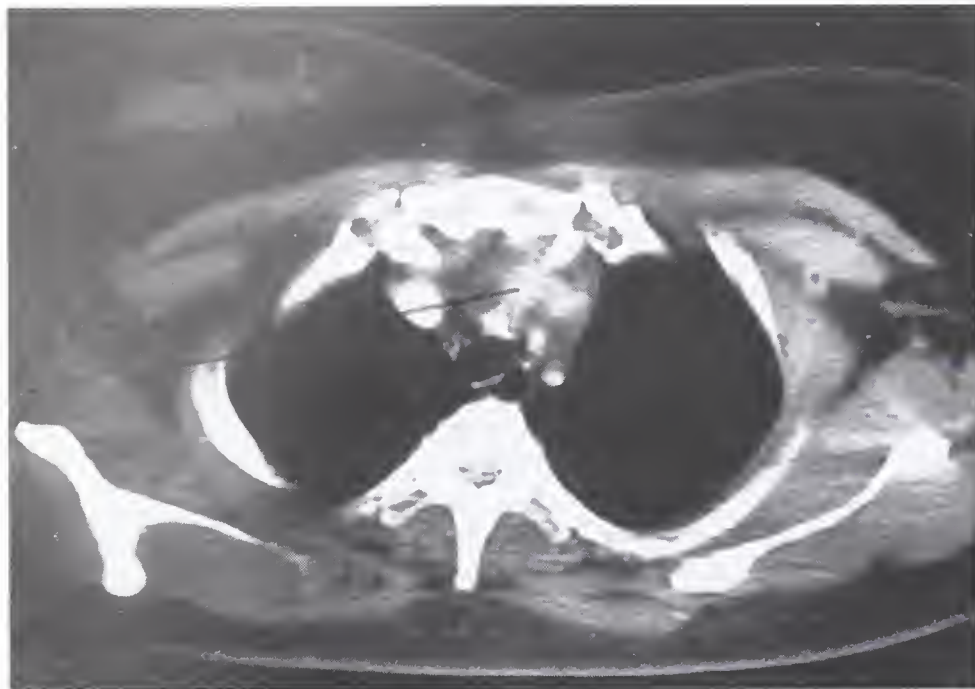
CT scan of the chest shows thymic enlargement.
